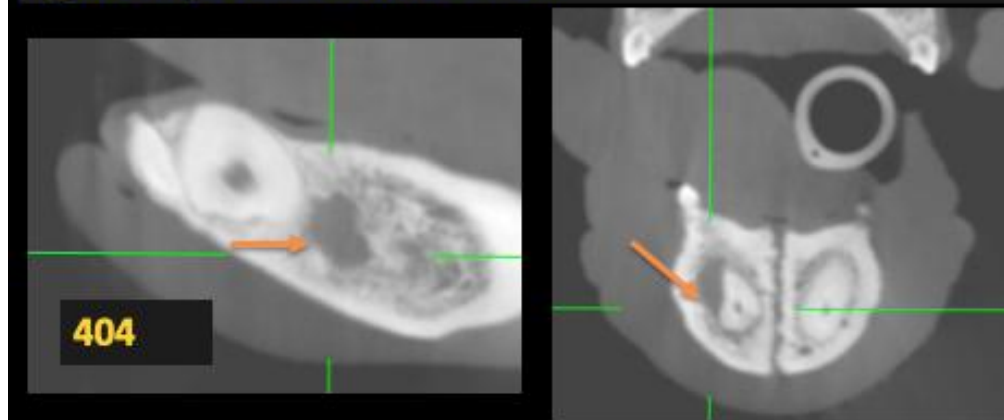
Periapical disease of Triadan 404
